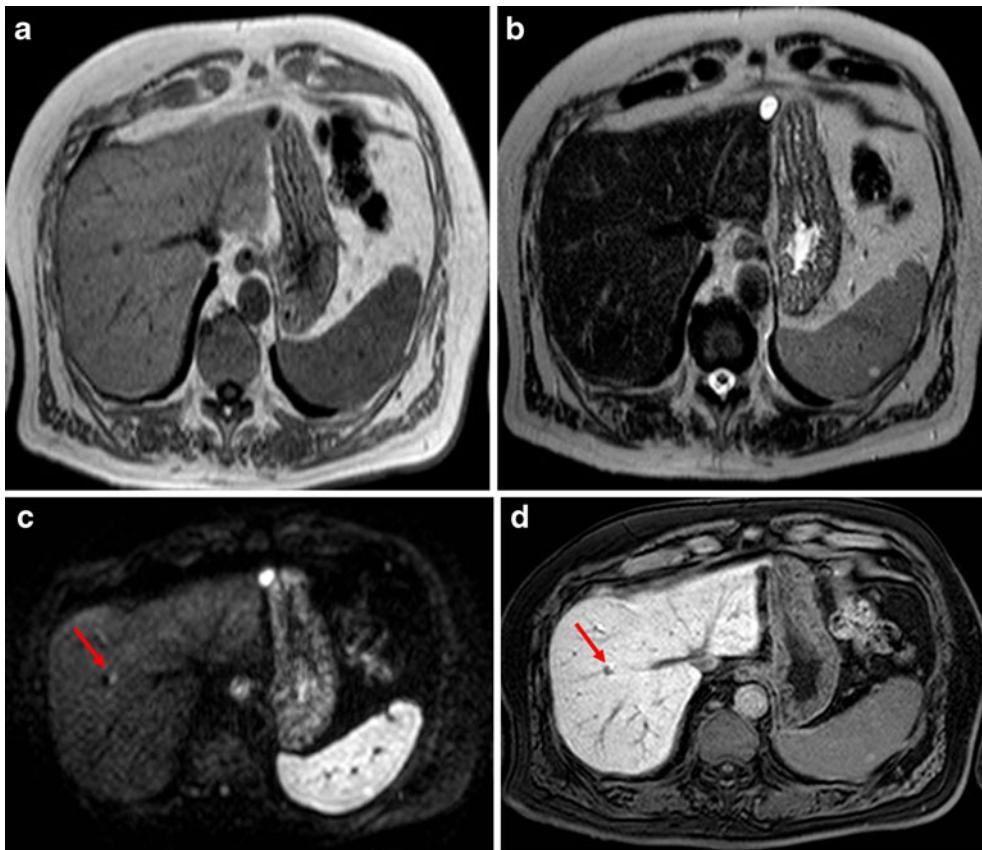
This figure demonstrates how combined assessment of DWI and Gd-EOB-DTPA imaging (c, d) is useful in detecting a small metastasis not identified on T1-weighted and T2-weighted imaging (a, b)
